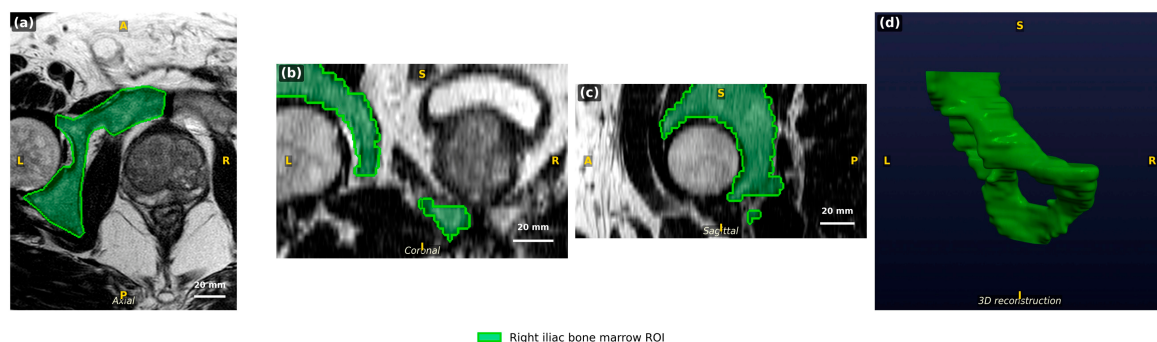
Manual segmentation of the right iliac bone marrow on multiparametric prostate MRI. Representative axial (a), coronal (b), and sagittal (c) views show the segmented region of interest (green overlay). Panel (d) shows the three-dimensional surface reconstruction of the segmentation volume. A = anterior; P = posterior; L = left; R = right; S = superior; I = inferior.
